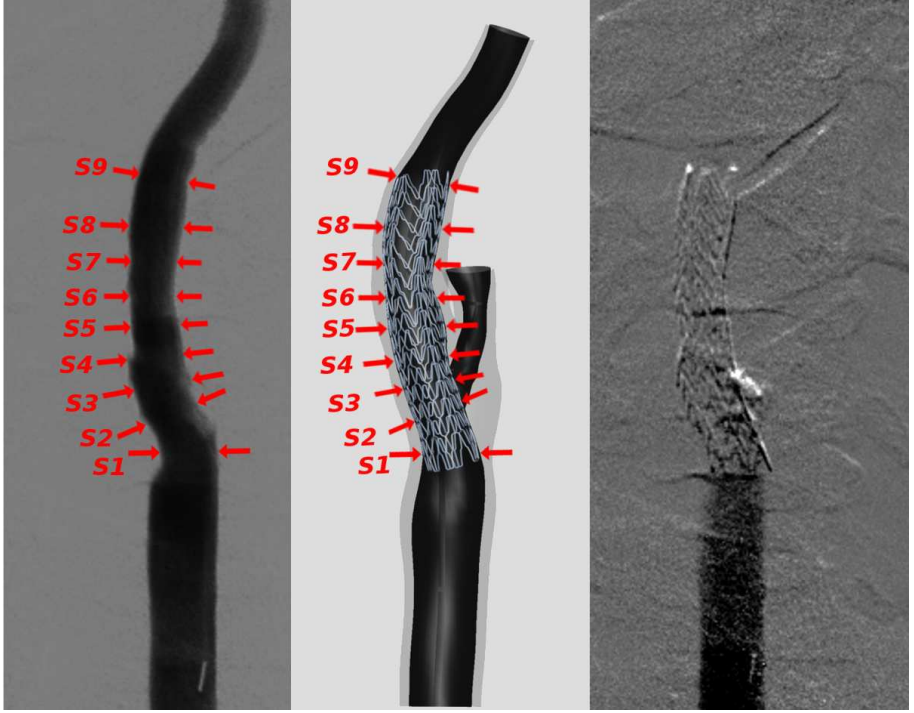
Qualitative comparison of the implanted stent configuration for patient B showing the clinical and numerical results. From left to right: angiography of stented lumen, numerical results, and X-ray of the implanted stent. Red arrows indicate the location of the measured diameters.
